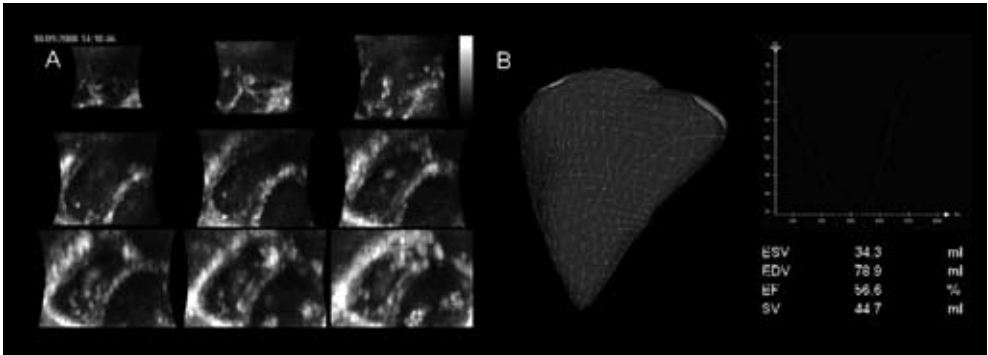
RT3DE right ventricular volumes and function assessment. Multi-slice (9-slice) 3D echocardiography obtained on-line by the full volume dataset shows multiple short-axis views of the right ventricle (panel A). Further off-line analysis of RT3DE datasets with dedicated software allows full-volume reconstruction of the right ventricle (panel B). The change in right ventricular volume during the cardiac cycle is presented graphically (right panel), with quantifications of end-diastolic and end-systolic volumes, ejection fraction and stroke volume.
